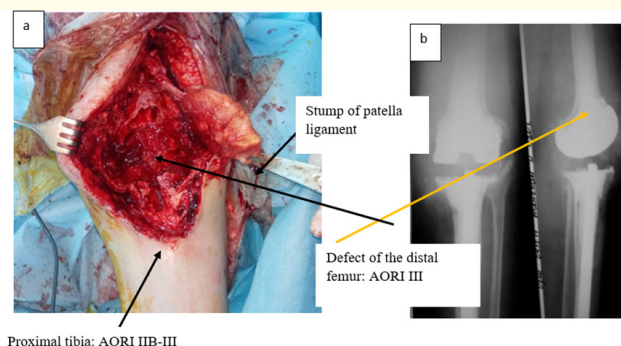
Intraoperative photo of the wound after surgical debridement T_0 and X-ray of the implanted PL spacer T_3 .
